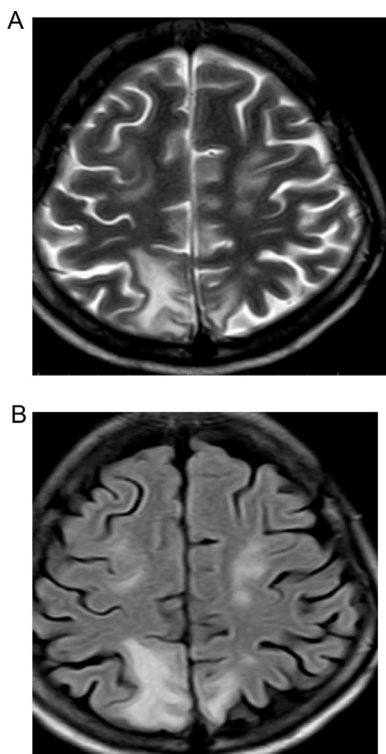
(A) Axial T2 weighted MRI image showing T2 high signal intensity in bilateral frontoparietal white matter. (B) Axial FLAIR weighted MRI image showing high signal intensity in the bilateral frontoparietal white matter (right>left) without obvious mass effect.
